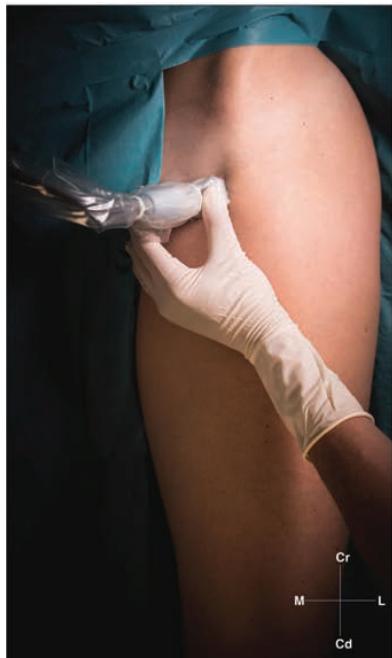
Transducer position and ultrasound image of an infrainguinal fascia iliaca block. FA, femoral artery; FN, femoral nerve; SM, sartorius muscle.
